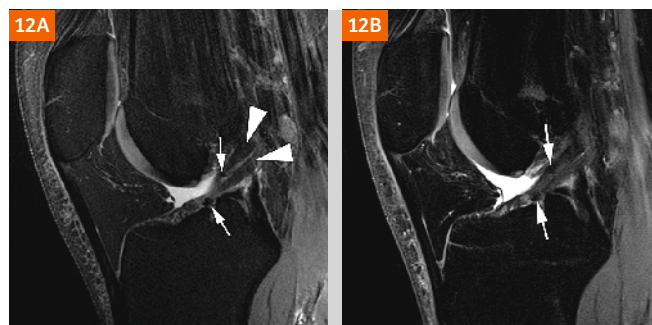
Anterior cruciate ligament (ACL) reconstruction. (12A) Sagittal proton density-weighted 7T MRI shows two intact hypointense bundles of an ACL reconstruction performed two years earlier (arrowheads). Note minor intraligamentous hypointense spot-like signal alterations representing minor metallic surgical remnants (arrows). (12B) Corresponding 3T image does not allow for differentiation of the two bundles as shown in 12A. Intraligamentous susceptibility is less pronounced at 3T compared to 7T.
